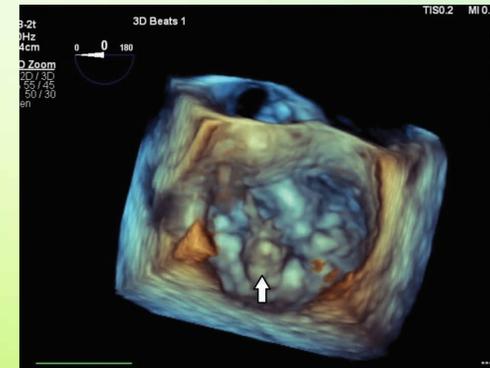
Transesophageal echocardiogram with 3D reconstruction – “Surgeon’s View” – of the mitral valve demonstrating P2 segment prolapse with flail (white arrow) due to a ruptured chordae tendinae.
